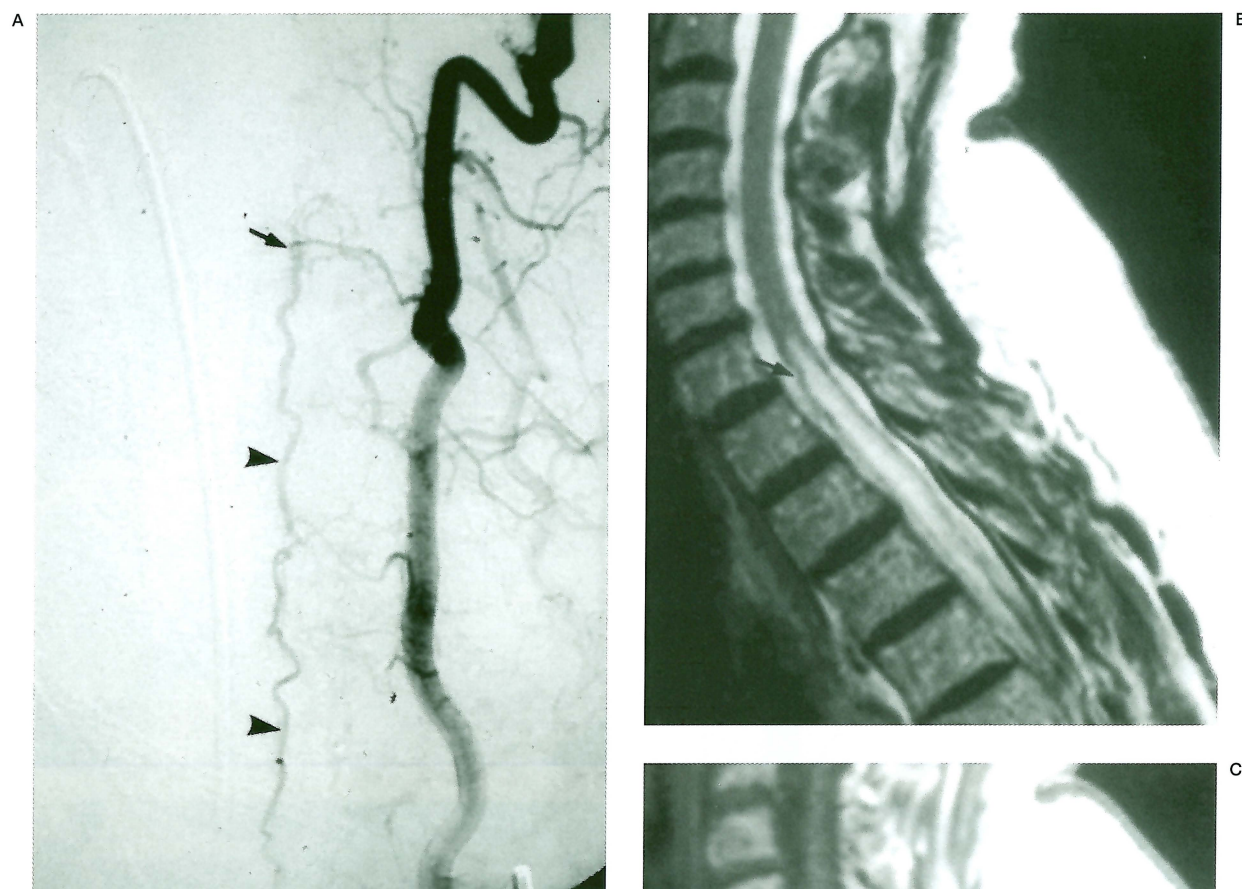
Dural AV shunt of the tentorium draining into the spinal cord veins (A and B). The MRI fails to demonstrate perivascular veins (C and D); note the dominant drainage into the ventral spinal cord vein.
